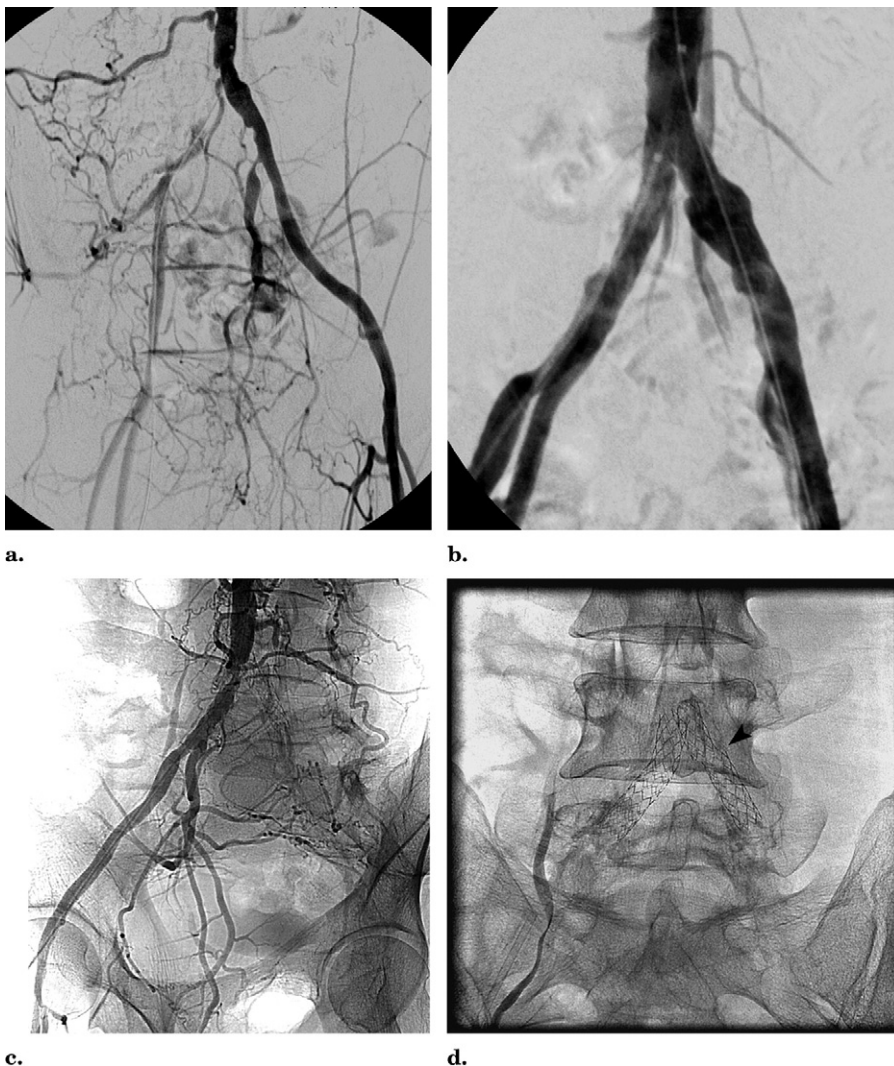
(a) Angiogram shows critical disease of the right common iliac artery. (b) Angiogram obtained after initial bilateral common iliac artery stent placement with balloon-expandable stents. (c) Angiogram obtained 2½ years later shows occlusion of the left common iliac artery stent (late filling of the distal common iliac, internal iliac, and external iliac arteries was seen) and in-stent stenosis of the right common iliac artery stent. (d) Anteroposterior spot radiograph shows complete fracture of the left common iliac artery stent (arrow-head) with some possible widening of the interstices of the right common iliac artery stent.
